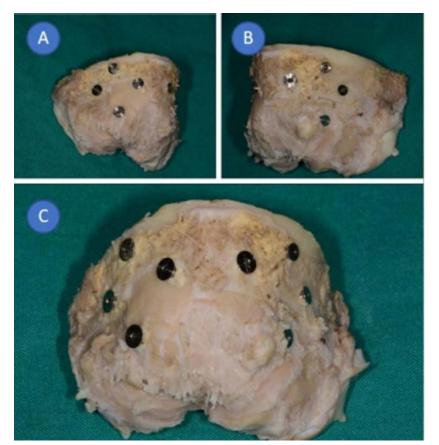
The bone defects marked with pins, prepared for cone-beam computed tomography analysis (A–C).
